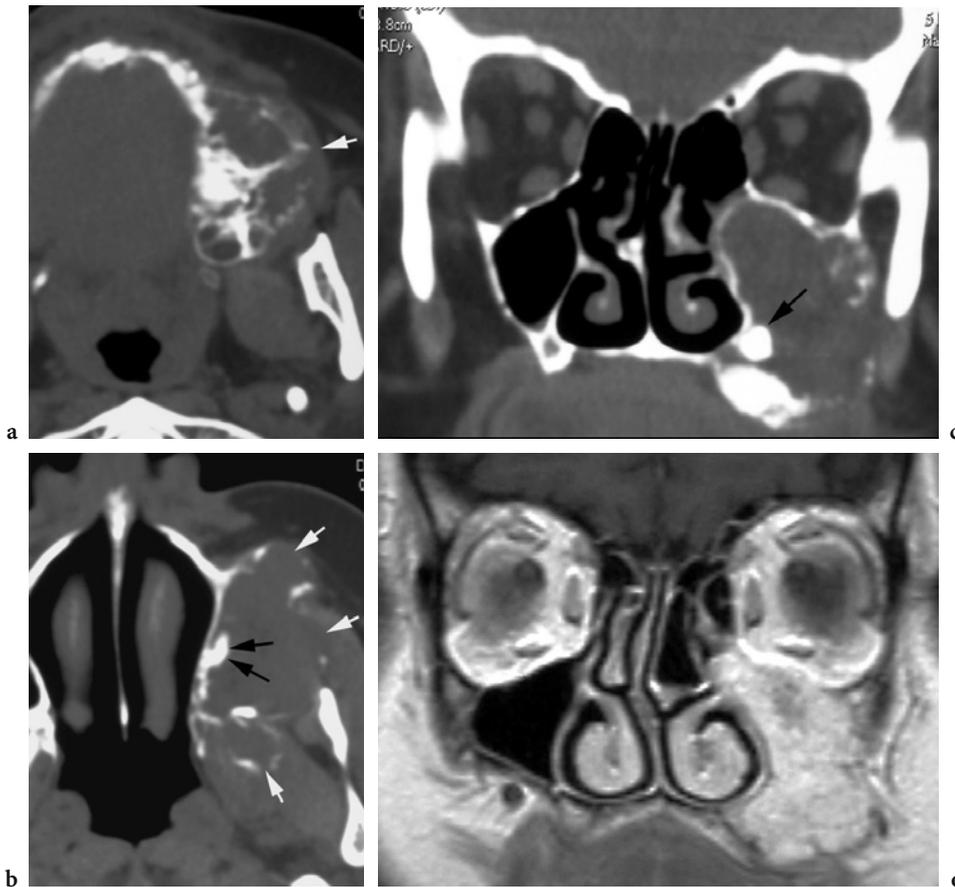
Calcifying odontogenic cyst (Pindborg tumor). a Axial CT scans show the irregular destruction of the alveolar process with spread into the buccal fat pad (*arrow*). b The lesion extends into the masticator space (*arrows*), irregular intratumoral densities are shown (*black arrows* in b and c). Mottled enhancing appearance of the lesion on post-contrast T1 coronal plane (d).
